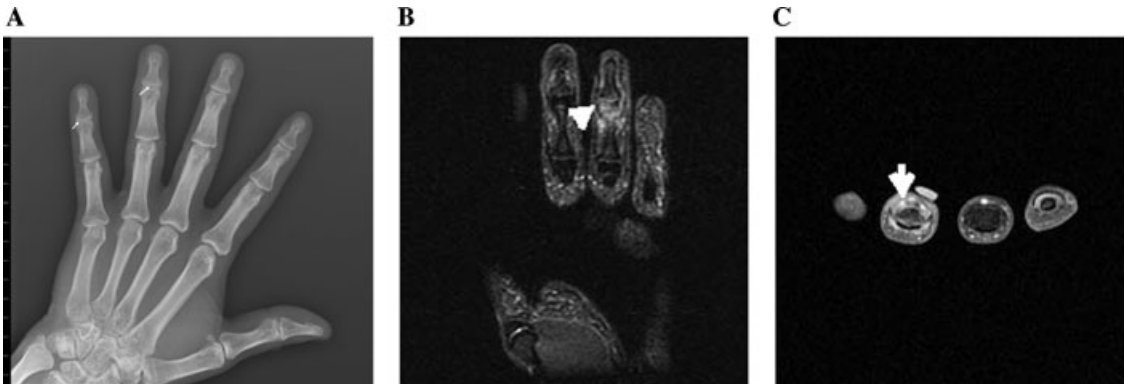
Postero-anterior view (A) of the left hand in a 50-year-old man. There is mild juxta-articular osteopenia and soft tissue swelling at the 4th DIP joint. The joints of the 4th and 5th fingers appear narrowed but on MRI only the 4th DIP joint is abnormal. Coronal STIR image (B) and axial T1-weighted image with fat saturation after gadolinium contrast administration (C) in the same patient. Imaging is focused on the 4th finger. On the STIR image there is bone marrow edema with a high signal in the distal aspect of the middle phalanx in the 4th DIP joint. A bright signal is also seen along the periosteum. (white arrow in B) Contrast-enhanced T1-weighted image demonstrates synovial enhancement (white arrow in C). The DIP joint and periosteal involvement is suggestive of PsA.
